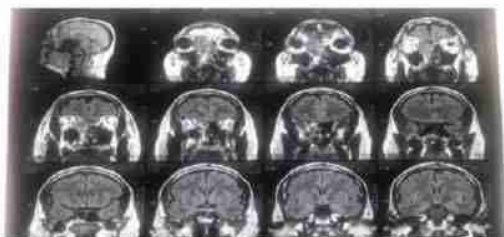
CT scan" coronal views: shows an opacification in right Ethmoid and frontal sinus. Mass is abutting the medial wall of orbit having mass effects of medial rectus and displacing eye ball laterally. Mass is also abutting septum to opposite side. With complete obstruction of right nasal cavity. Erosion of medial wall of maxillary sinus is also noted.
